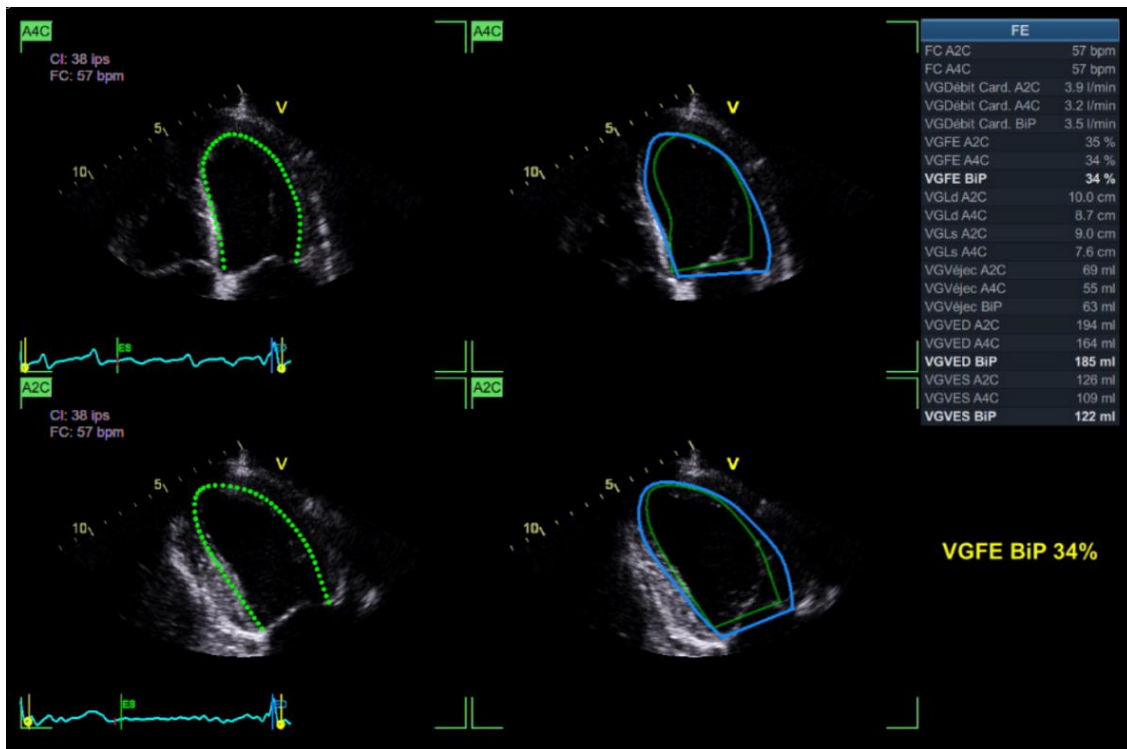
Transthoracic echocardiographic image showing a reduced left ventricular ejection fraction (LVEF)
